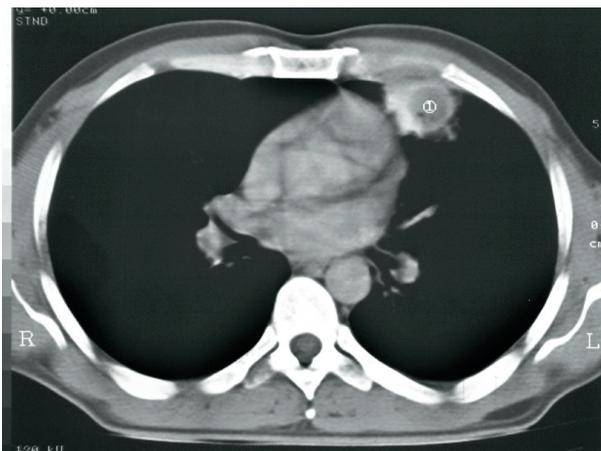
Computed tomographic scan of the thorax showing a cavitating lung mass.
